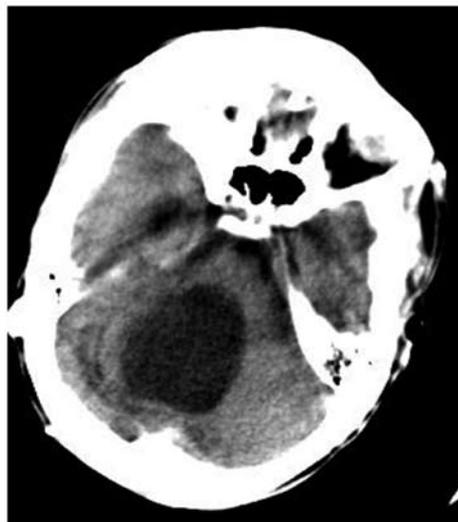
CT examination. Cystic enlargement of the fourth ventricle
